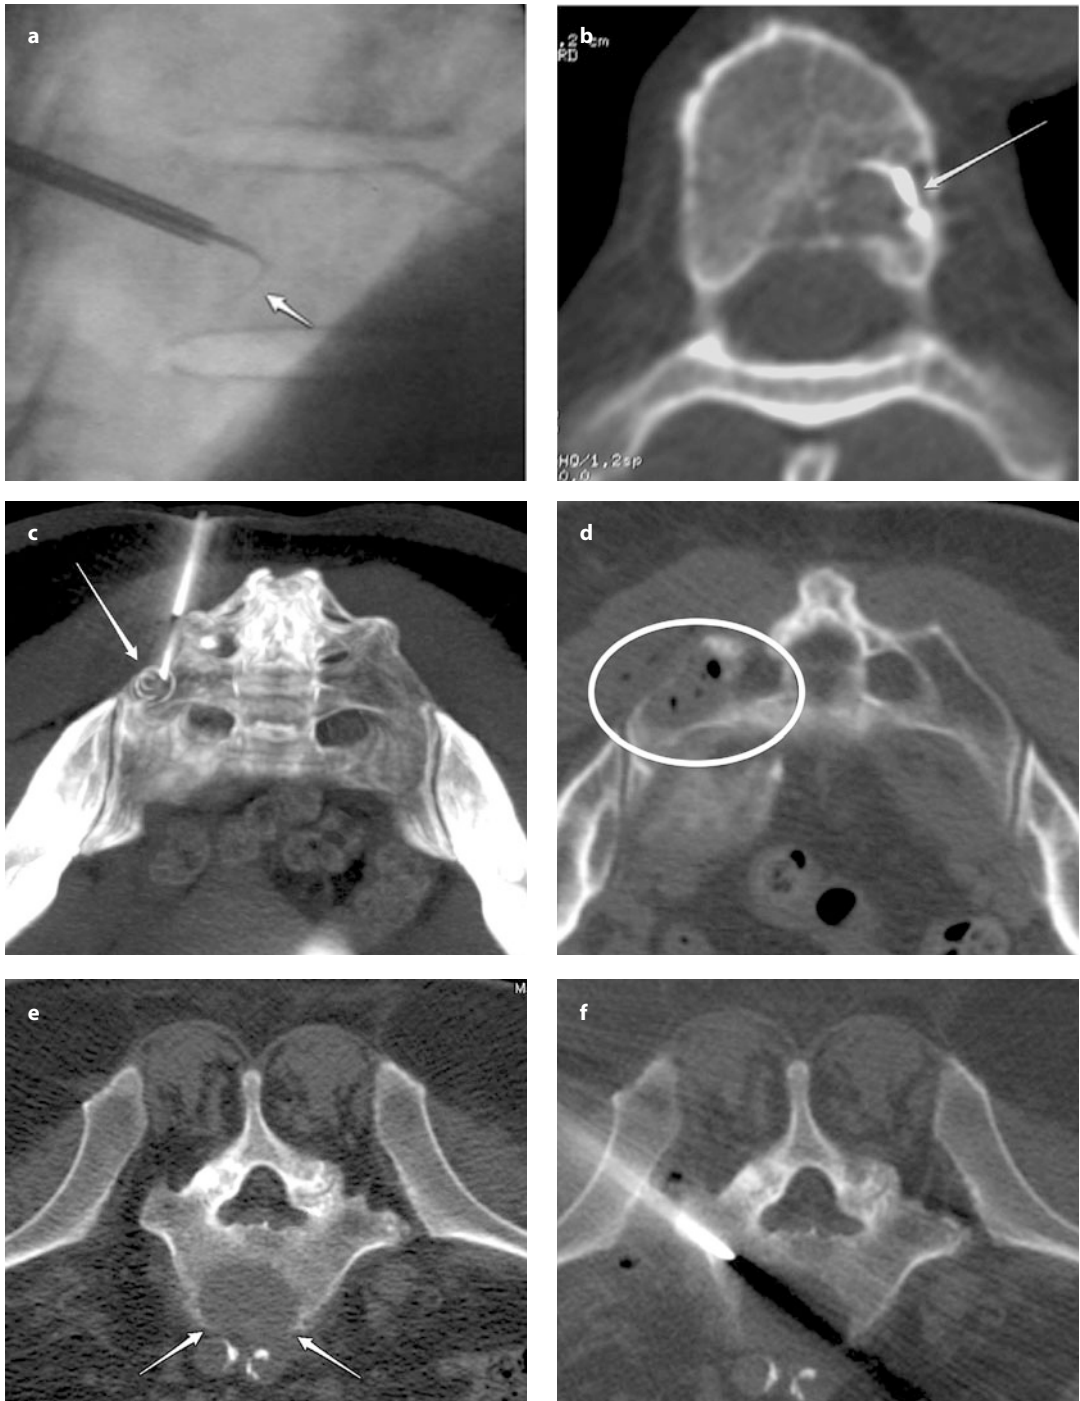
Lateral fluoroscopic view of a spring-shaped radiofrequency electrode inside a vertebral body during deployment (*arrow*) by the transpedicular route in a case of breast-cancer metastasis (a). Axial CT slice showing the same case with one wire of the electrode highlighted (*arrow*) (b). Axial CT slices showing radiofrequency ablation of a colorectal-cancer metastasis of the right sacral wing with a spring-shaped electrode (*arrow*) *in situ* through a posterior paravertebral approach with gas inside the hollowed lesion at the end of the procedure (*circle*) (c and d). Radiofrequency ablation of a L5 somatic metastasis of myeloma (*arrows*) approached by the trans-iliac route (e and f)
